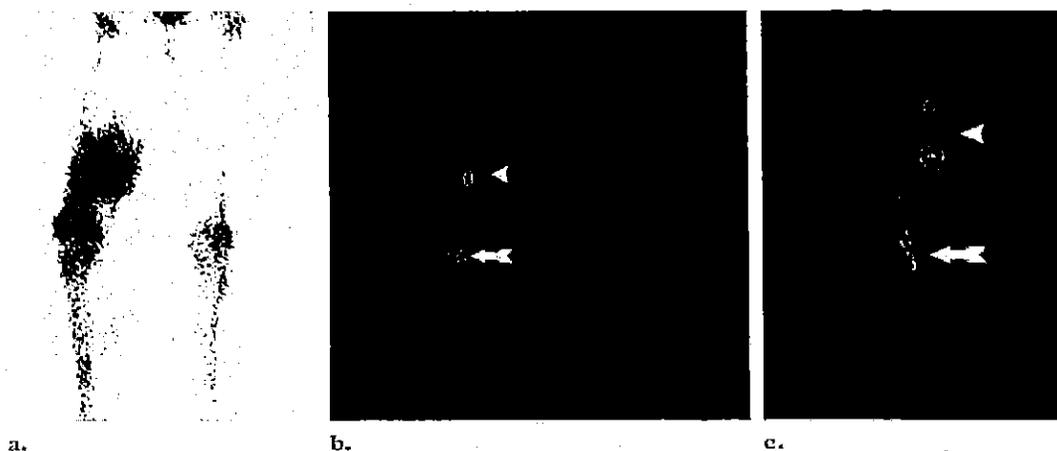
Demonstration of the extent of malignancy in a young male patient with sarcoma. (a) Anterior whole-body scan shows definite involvement of the medial soft tissue in the lower right thigh. However, the presence of bone involvement is less certain. (b, c) Anterior (b) and lateral (c) fused SPECT/CT images show the soft-tissue involvement (arrowhead) along with osseous disease (arrow). Although bone scanning is typically a sensitive examination, there may be issues with specificity or localization of lesions.
